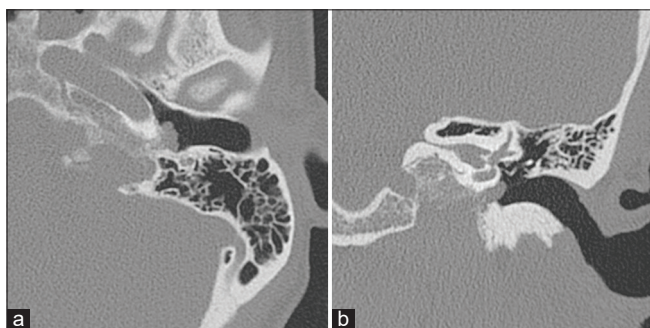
A 37-year-old woman with glomus jugulotympanicum. (a) Axial high-resolution computed tomography and coronal multiplanar reformation image (b) through the middle ear shows presence of permeative bony destruction in the region of the jugular bulb, associated with presence of abnormal soft-tissue in the hypotympanum.
